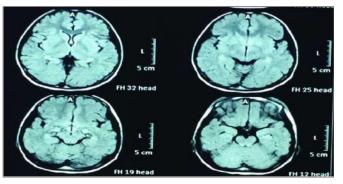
MRI brain on 6 weeks follow-up showing complete resolution of abnormal hyperintense signals.
